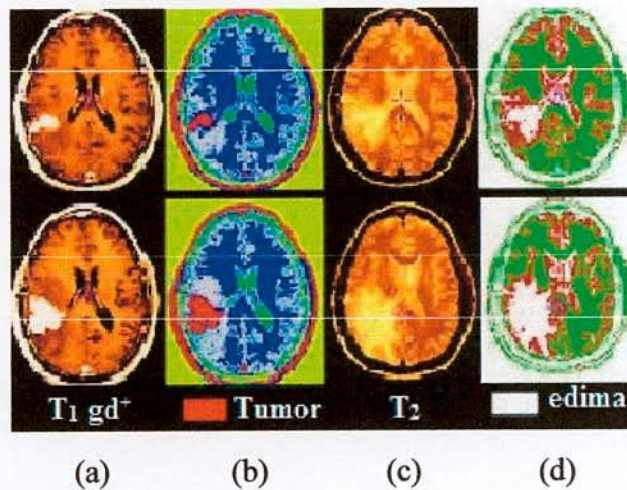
Region growing based segmentation (a) T_1 weighted brain MRI image (b) red marked tumor detection (c) T_2 weighted brain MRI image (d) white marked edema detection
